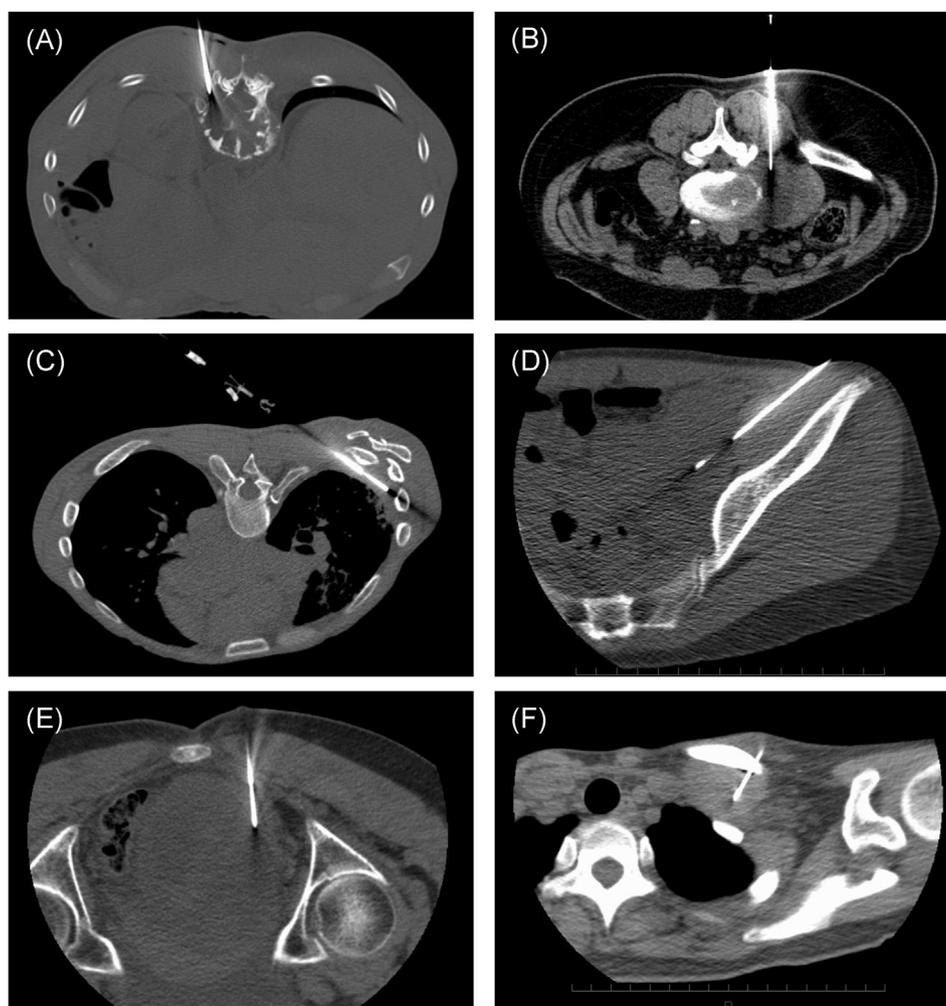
Typical axial views of computed tomography indicating complicated biopsy routes categorized into mainly 6 types in the present study.
